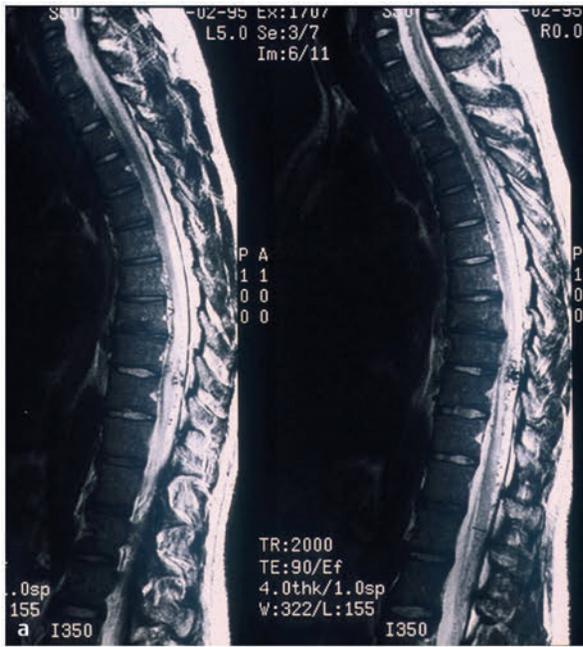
(a,b) Magnetic resonance images showing a perimedullary fistula in a pediatric patient. (c) Angiogram confirming the diagnosis of perimedullary arteriovenous fistula.
